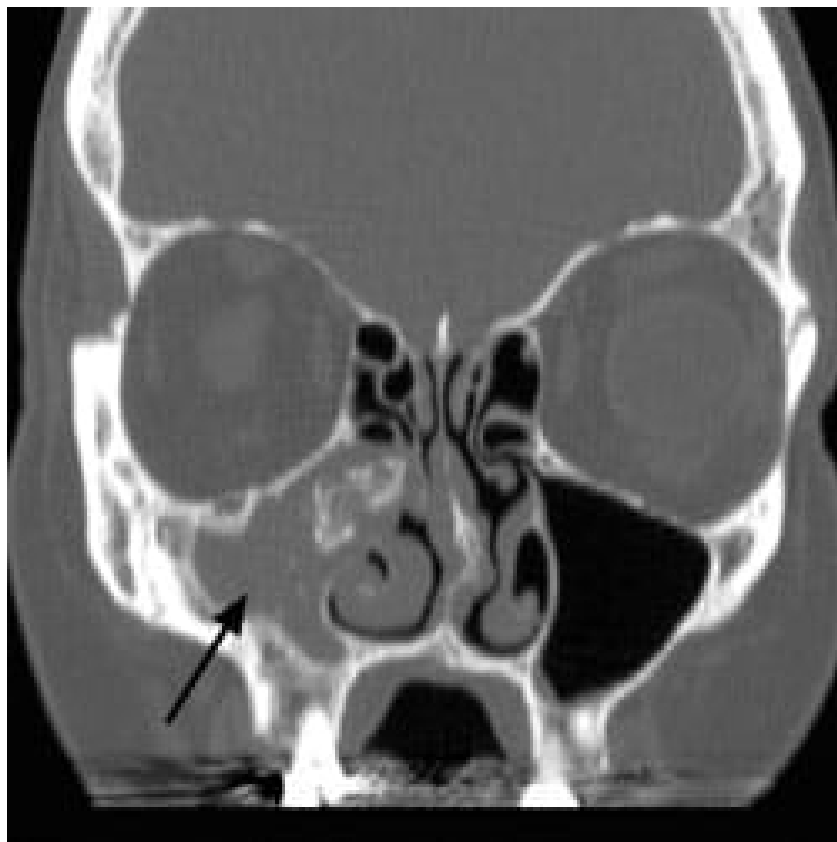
CT showing Right Fungal Ball
